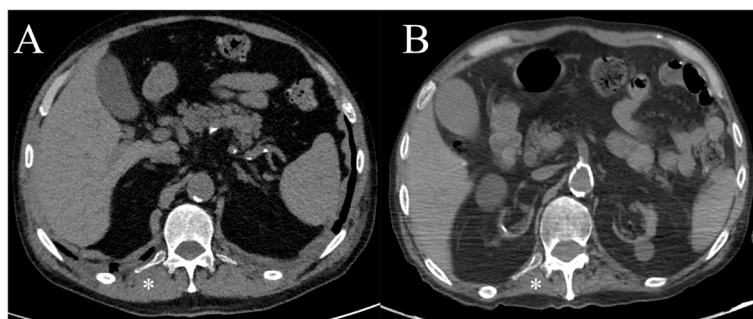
Axial unenhanced CT images of the same patient after 2 months from the ICU admission for severe COVID-19. Note how the muscle mass in the left para-vertebral muscle at the level of T12 was drastically reduced between the admission (asterisk in A) and the follow-up imaging study (asterisk in B)
